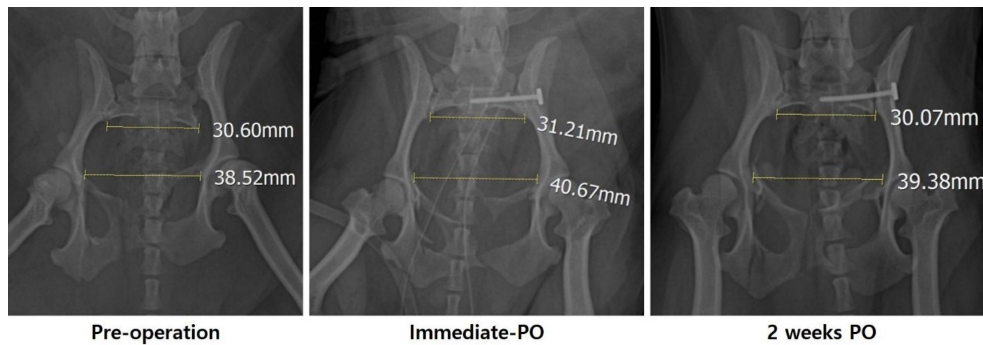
Radiographic examinations of Case 1. Radiographic examination to determine the pelvic canal ratio was performed three times: preoperative, immediate postoperative, and 2 week postoperative examinations. PO, Post-operation.
